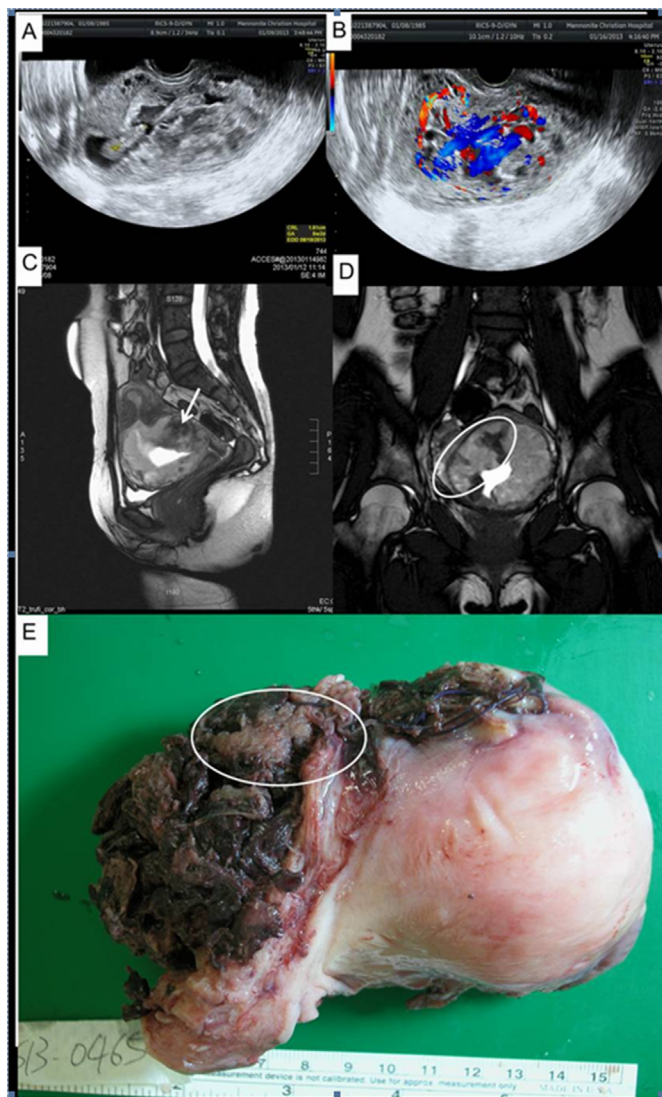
(A) Ultrasound grayscale image of the uterus reveals bulging of the lower uterine segment with multiple anechoic irregular sinuses. (B) Color mapping with Doppler integration depicts copious flow in the placental–myometrial junction. The subplacental space is unclear and turbulent lacunar flow is observed. (C) Sagittal T2 true FISP image shows placental–myometrium invasion that traverses and bulges the lower uterine segment (white arrow). Discontinuity and irregularity of the posterior serosal surface is demonstrated. (D) Coronal T2 true FISP image shows heterogeneous hyperintense placenta encircling the whole lower uterine segment. Low signal intensity bands are noted on the right side. (E) Rupture of the right side of the uterine wall with bulging placenta (white oval circle). FISP = fast imaging with steady state precession.
